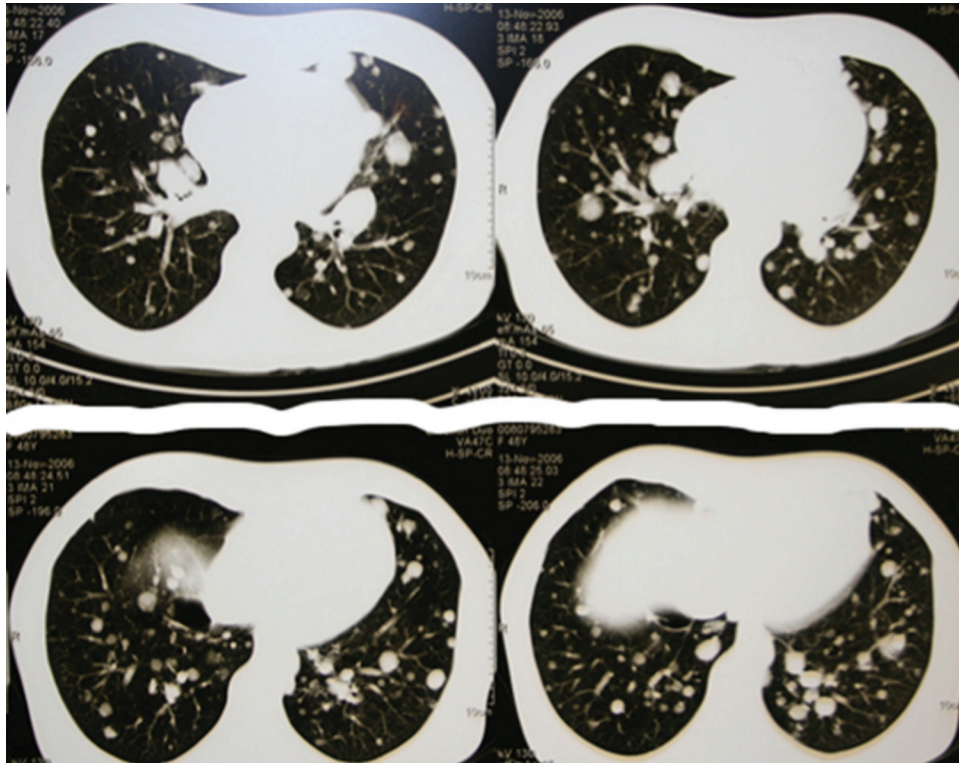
Multiple lung leiomyoma metastatisation pattern in chest CT.
